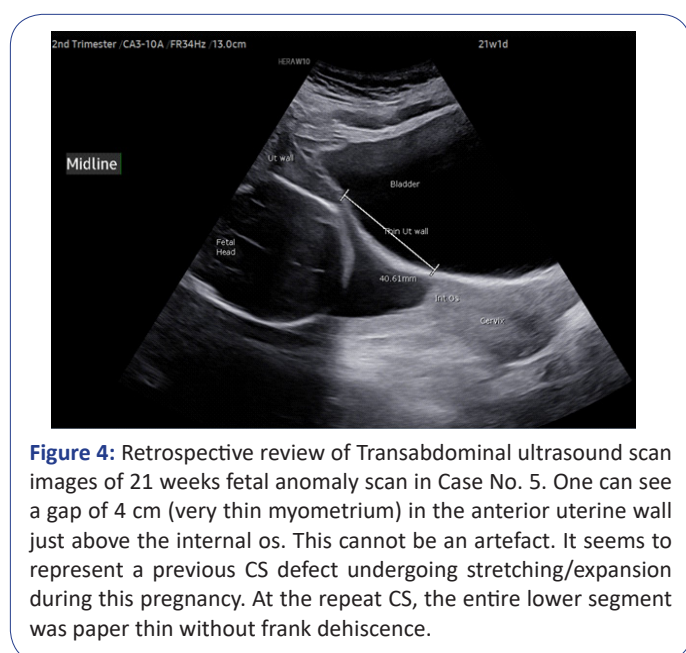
Retrospective review of Transabdominal ultrasound scan images of 21 weeks fetal anomaly scan in Case No. 5. One can see a gap of 4 cm (very thin myometrium) in the anterior uterine wall just above the internal os. This cannot be an artefact. It seems to represent a previous CS defect undergoing stretching/expansion during this pregnancy. At the repeat CS, the entire lower segment was paper thin without frank dehiscence.
